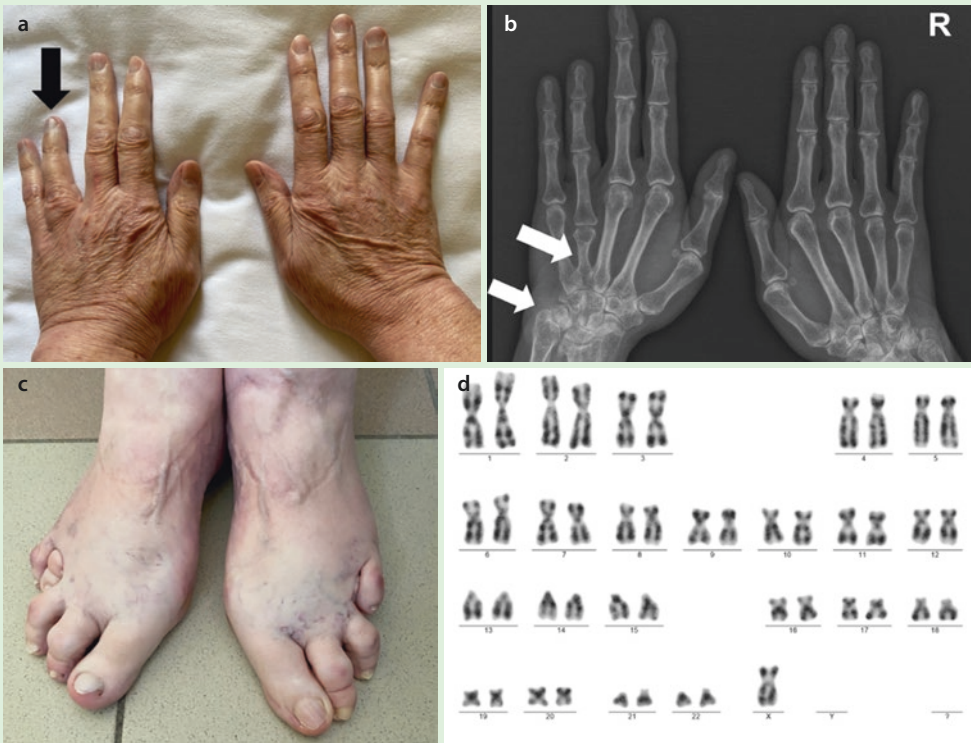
a Photograph of the patient's hands shows the conspicuously shorter left fourth finger. b An x-ray of the patient's hands shows the short left fourth metacarpal and the Madelung deformity—subluxation of the distal end of the ulna (arrows). c The patient's feet with a short fourth toe. d Karyogram
